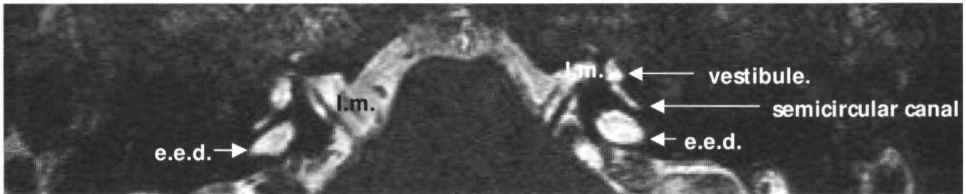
High resolution (CISS) heavily T2 weighted MR image of the temporal bone at the level of the internal meatus (I.m.). Typical example of the enlarged endolymphatic duct (e.e.d.) on both sides.
